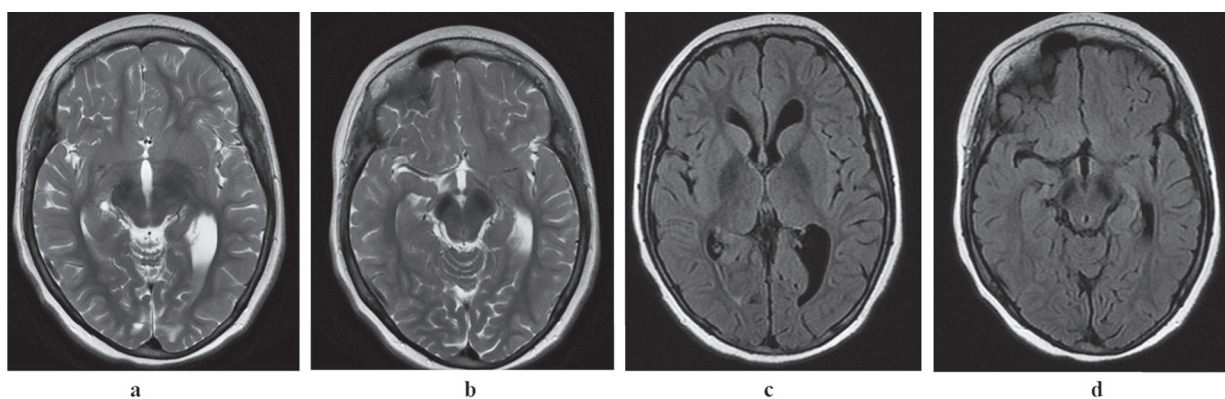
Iron accumulation in the substantia nigra and globus pallidus in T2-weighted (a, b) and FLAIR (c, d) scans
